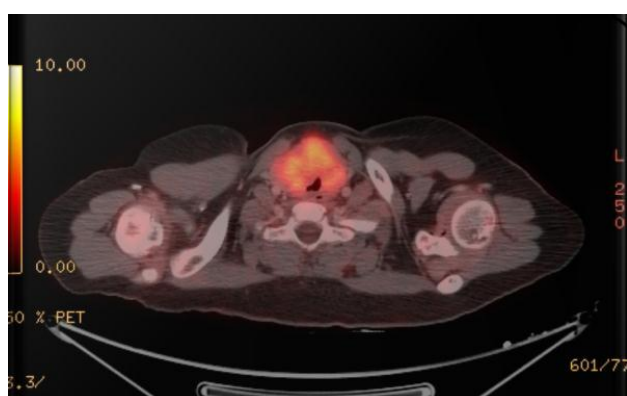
PET CT (pre chemotherapy): hypermetabolic lesion involving the thyroid gland (SUV Max 9.2) and bilateral neck nodes.
